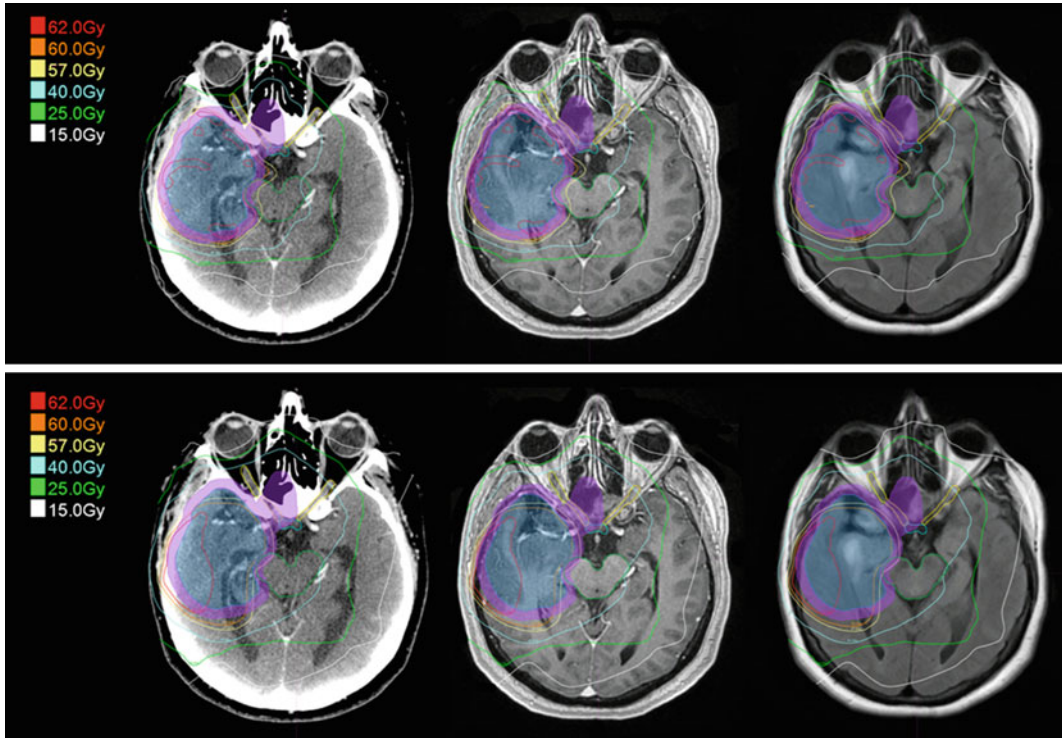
A comparison of intensity-modulated radiation therapy (IMRT) and 3-dimensional conformal radiation therapy (3DCRT) for the same patient as in Fig. 1 with a resected glioblastoma. The *top row* is the IMRT plan as seen on the computed tomography (CT), T1-weighted post-gadolinium and T2-weighted FLAIR magnetic resonance images, respectively, from *left to*
